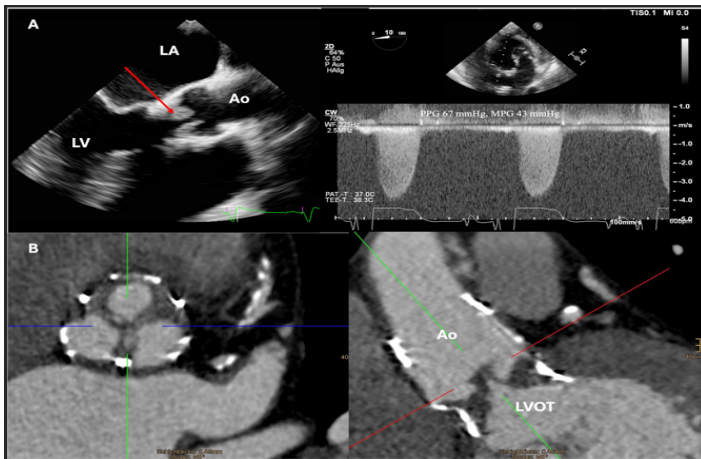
A. Transesophageal examination, thickening of the leaflet (arrow), and increased gradient through the valve are visible. B. Computer tomography. Thickening at the junction of the stent and the prosthesis leaflets (arrow) is visible. Ao - aorta; LVOT - left ventricular outflow tract; LA - left atrium; LV - left ventricle.
